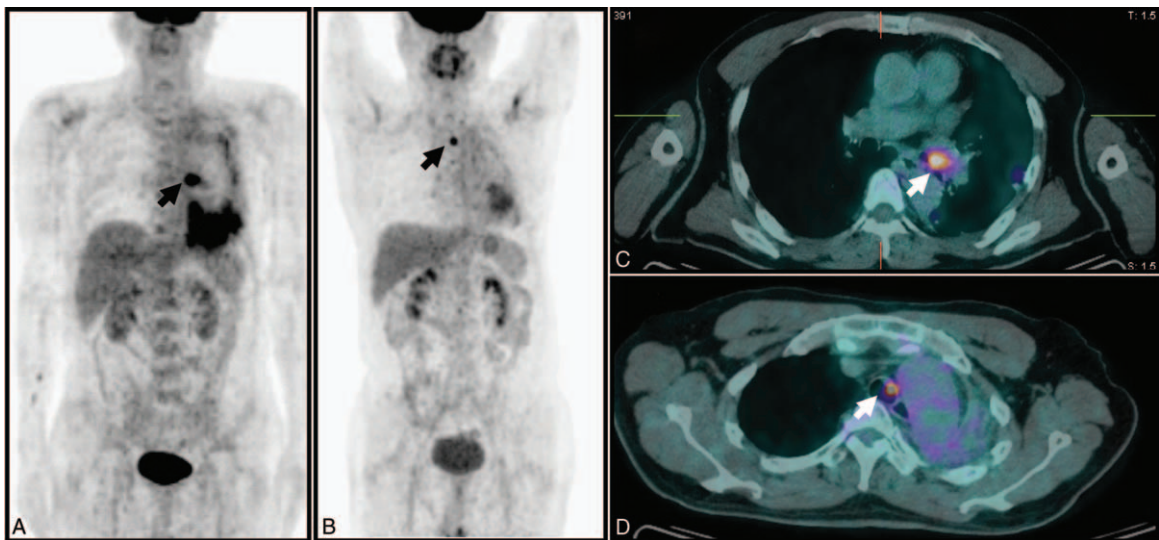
PET/CT scans showed the mass with increased 18-FDG uptake in left main bronchus (arrow) at the initial diagnosis of lung malignancy (A, coronal view; C, transverse view). At first occurrence of second primary lung cancer in trachea, the small mass (arrow) was observed and its 18-FDG uptake was significantly high (B, coronal view; D, transverse view). 18-FDG, 18-fluorodeoxyglucose, PET, positron emission tomography, PET/CT, positron emission tomography/computed tomography.
